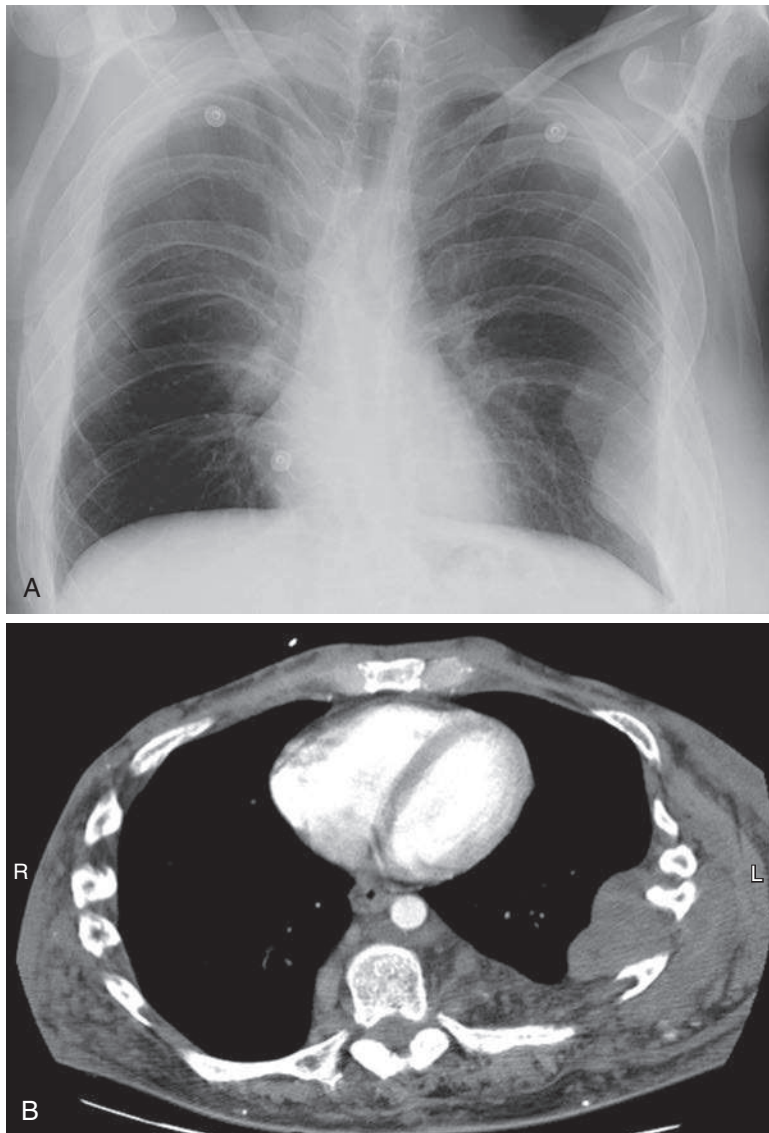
A, This patient with neurofibromatosis has bilateral, elongated, tapered, smooth, peripheral masses, and multiple ribs are inferiorly eroded. B, Computed tomography confirms the peripheral masses with extension of the left lateral mass through the chest wall. The posterior extension of the mass was not suspected from the radiograph.
